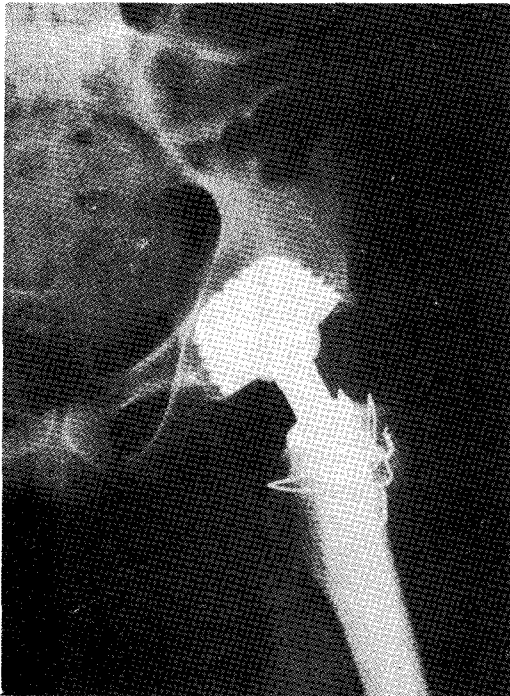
Post-operation and radiation x-ray shows no evidence of ectopic bone formation (Grade 0).
